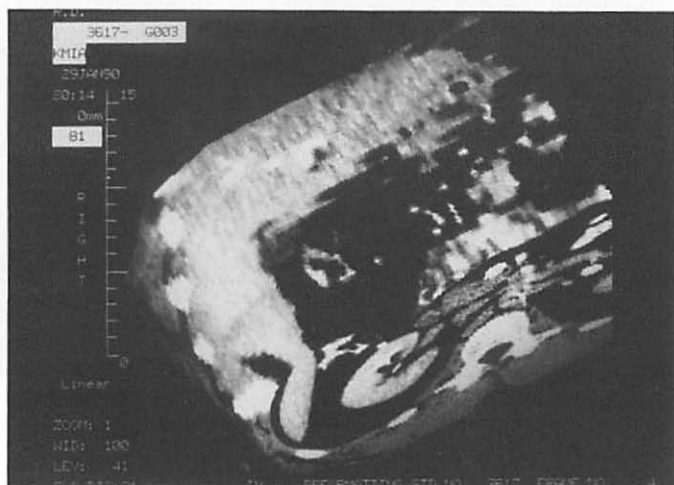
The region of the liver is reconstructed as a block. The CT values are added to the surface. The liver is seen from anterior and left, from inferior the kidney and the spine can be seen clearly.
